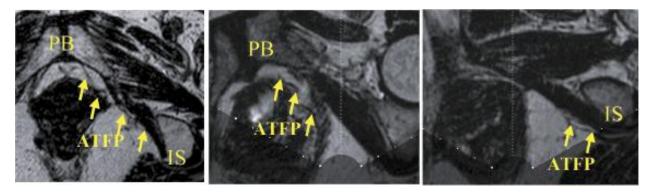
Figure A,B,C Pre-operative 3T MRI image (A, left) and the real-time intra-operative virtual MRI images (B, middle, and C, right) to visualize the AFTP in adjacent tomograms, which were reconstructed according to the surgeon's finger manipulations
